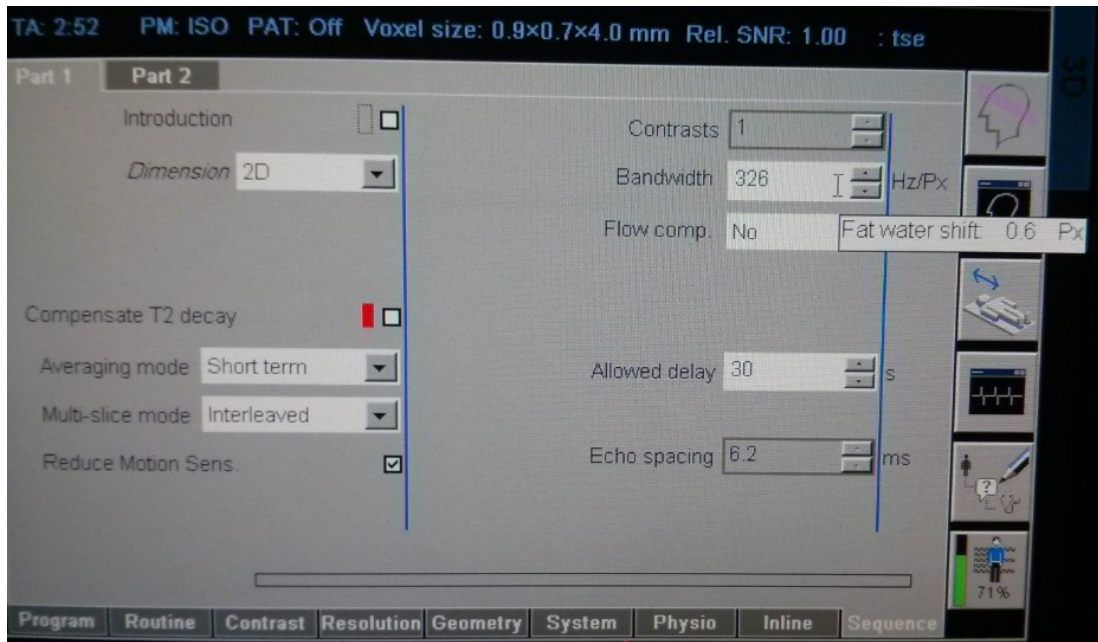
Siemens' Syngo MRI Software. Sequence menu. Receiving BW and Chemical Shift per Pixel.
